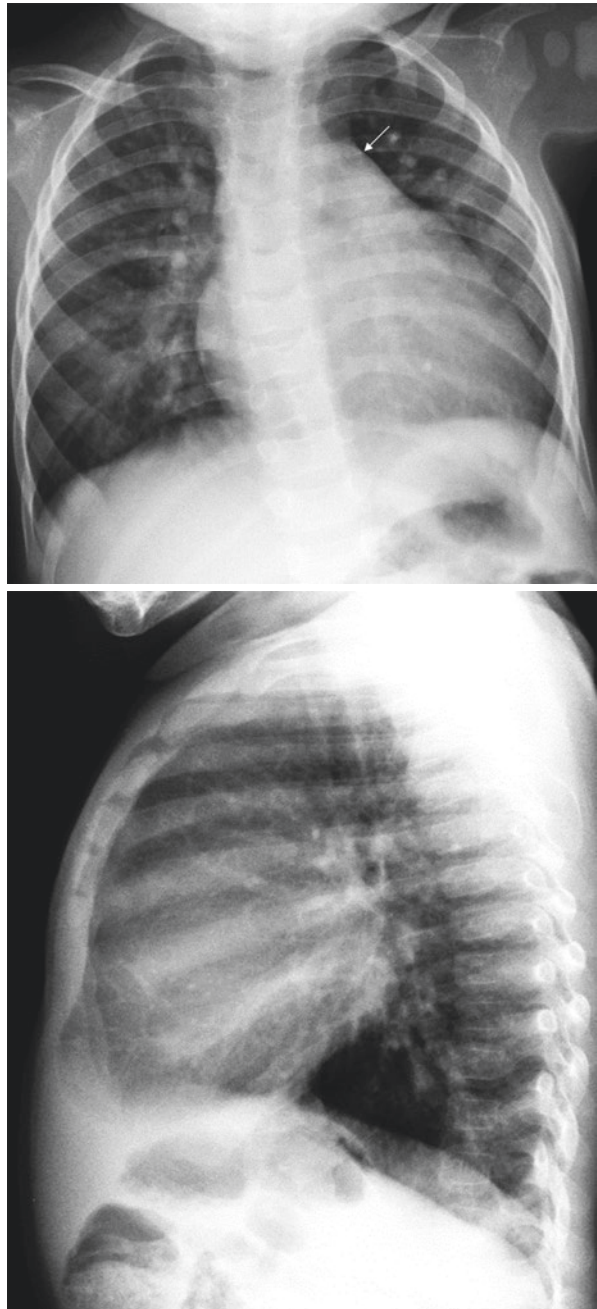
Frontal chest radiograph of a 6-month-old male with Ebstein's anomaly shows cardiomegaly and decreased pulmonary vascularity
